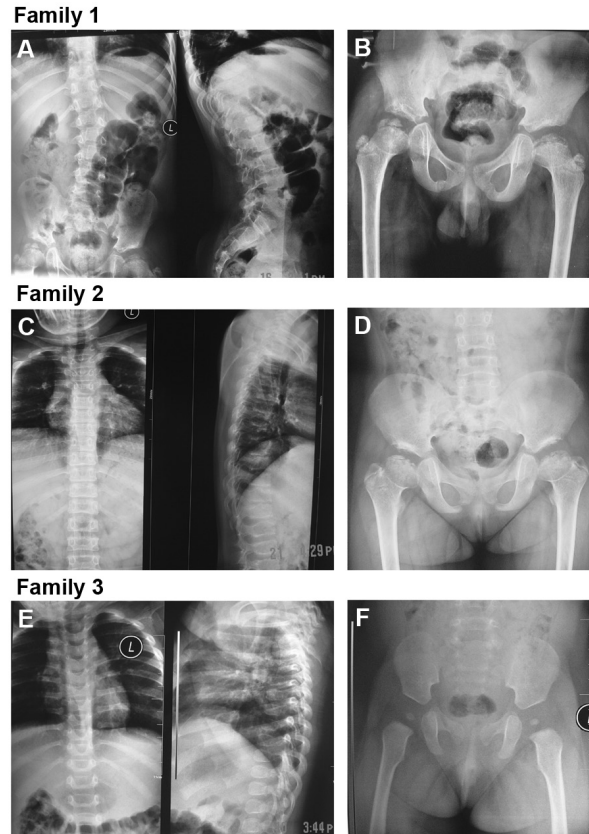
Radiograph of the probands' spine and pelvis. A. Family 1, spine. B. Family 1, pelvis. C. Family 2, spine. D. Family 2, pelvis. E. Family 3, spine. F. Family 3, pelvis.
